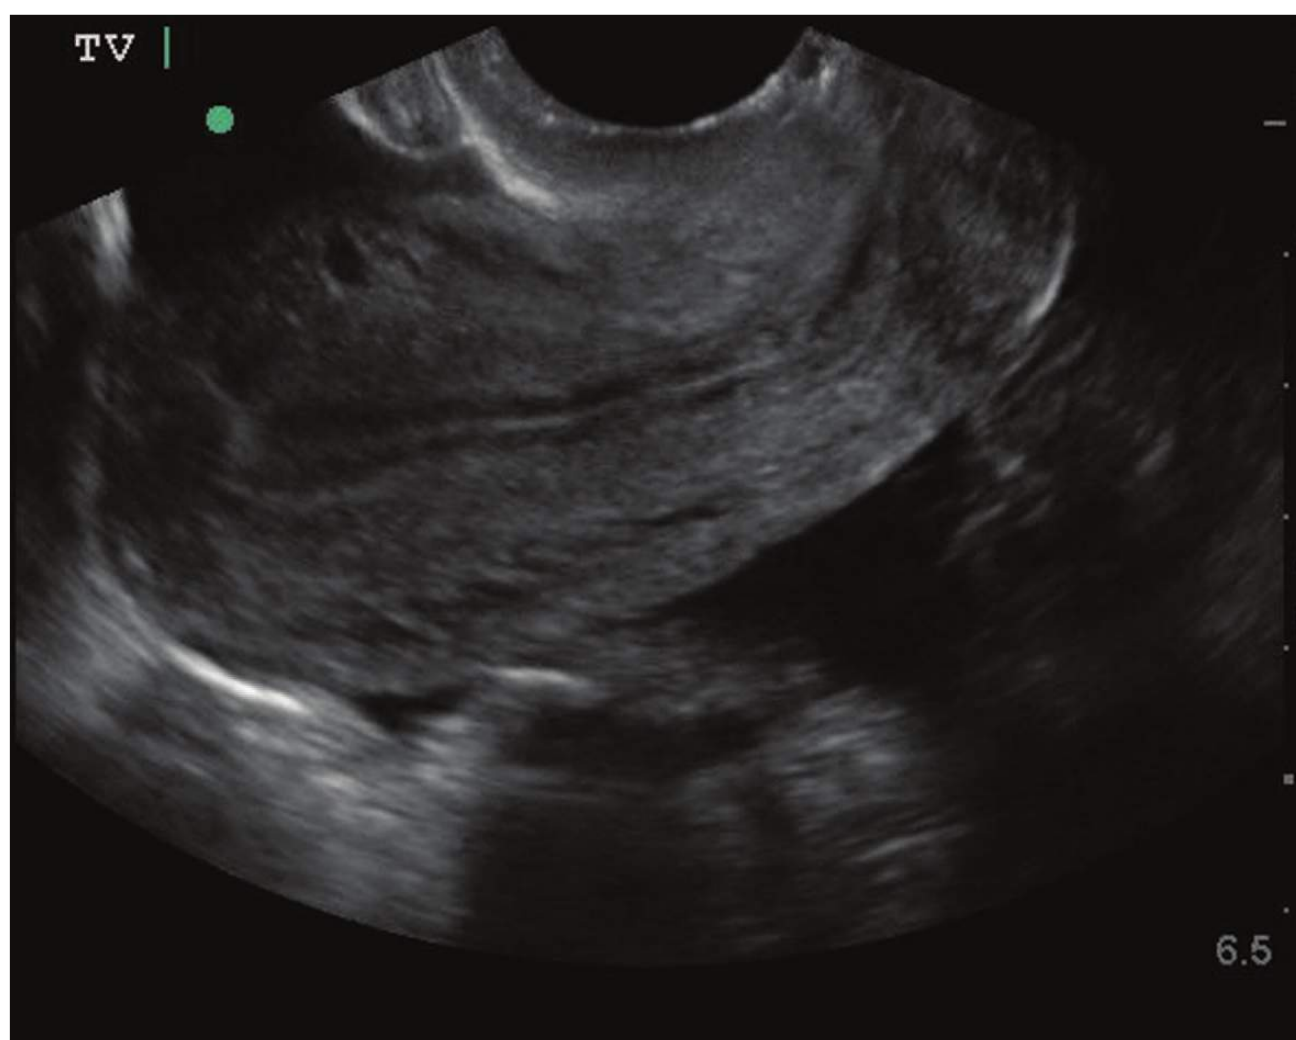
■ Empty Uterus. Free fluid seen in the pelvis in this patient with an empty uterus is concerning if ectopic pregnancy is suspected. Ectopic pregnancy should be strongly suspected if a transvaginal ultrasound reveals an empty uterus in the setting of a serum quantitative hCG level above the institution’s discriminatory zone. (Photo contributor: Lauren Oliveira, DO.)
